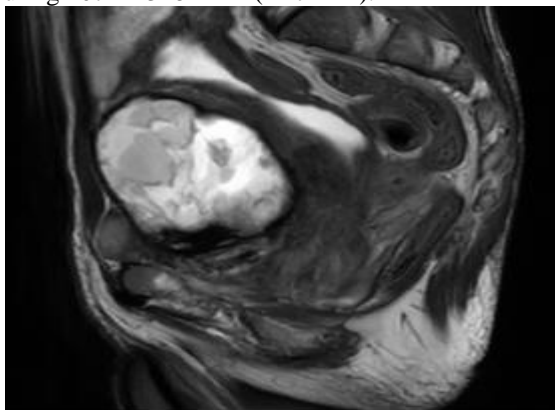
MRI showing a large prostatic process in heterogeneous T2 signal containing an area with T2 hypersignal.
